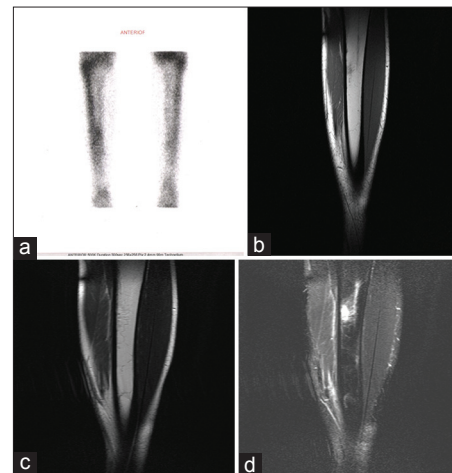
(a) Bone scan revealed intense well defined area of increase tracer up take in middle thirds shaftof right femur, (b) T1-weighted coronal magnetic resonance imaging (MRI) figure reveled normal signal intensities, (c) T2-weighted coronal MRI figure revealed normal signal intensities, and (d) short-tau inversion-recovery coronal MRI figures revealed focal area of hyper-intense intensity in middle third shaft of right femur. Diagnosed as case of Grade I stress fracture
